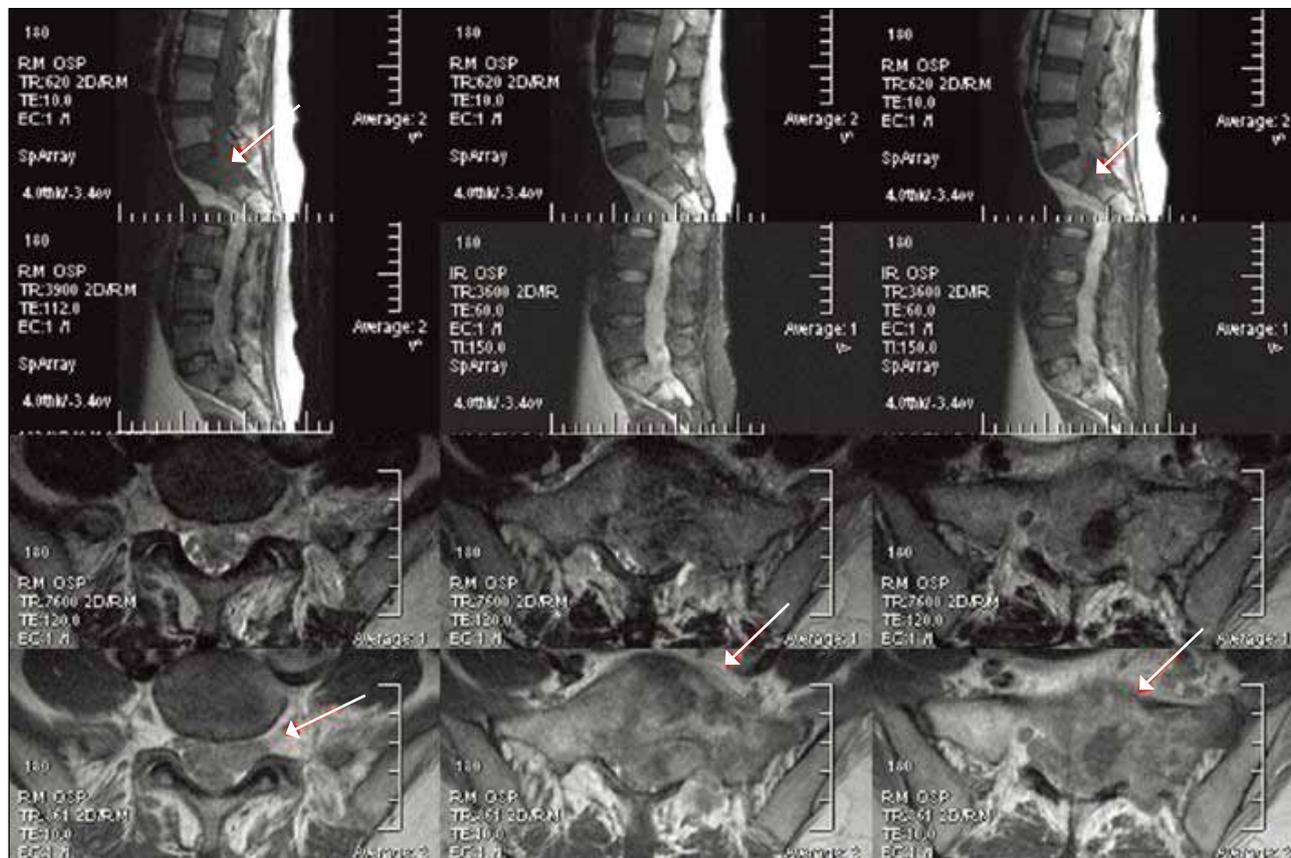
Magnetic resonance imaging (T1, T2 sagittal and axial) demonstrated a large irregular extradural mass (arrows) infiltrating the spinal canal at the L1 to S2 vertebral level with obliteration and compression onto the S1 and S2 region of the spinal canal. The mass extended through the left S1 sacral foramina to involve the left paraspinal muscle. The mass was heterogeneously enhanced (not shown).
